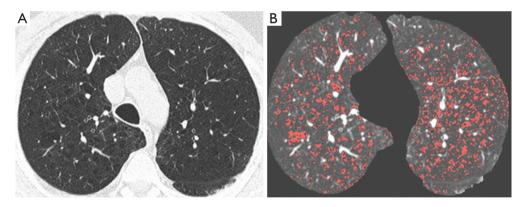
Low-dose CT image at aortic arch (A) in one subject undergoing lung cancer screening showing multiple areas of decreased attenuation bilaterally. In (B) the pixels with density values below -950 HU (RA950) are outlined in red. Adapted and reproduced with permission from reference (56). CT, computed tomography.
